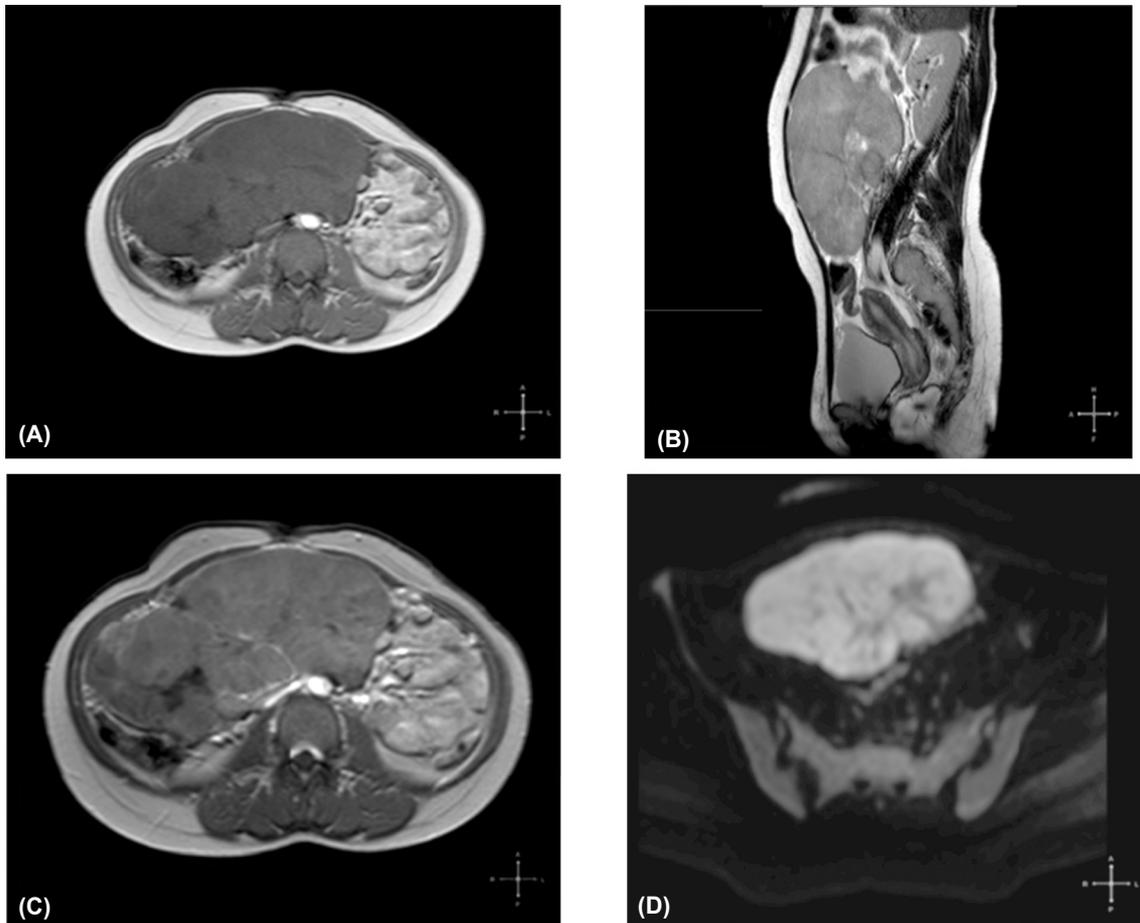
Female patient aged 23 years, with large solid pelvi-abdominal mass on ultrasound. (A) Sagittal T2 WI, (B) Axial T1 WI, (C) Axial T1 post-contrast (D) DWI ($b\text{-value} > 1000\text{sec/mm}^2$). The lesion shows hyperintense signal on T2, hypointense signal on T1WI, shows moderate enhancement in the post contrast study and shows restricted diffusion on DWI suggesting malignancy. The ADC value was $0.87 \times 10^{-3} \text{ mm}^2/\text{s}$. Final diagnosis: Granulosa cell tumor.
